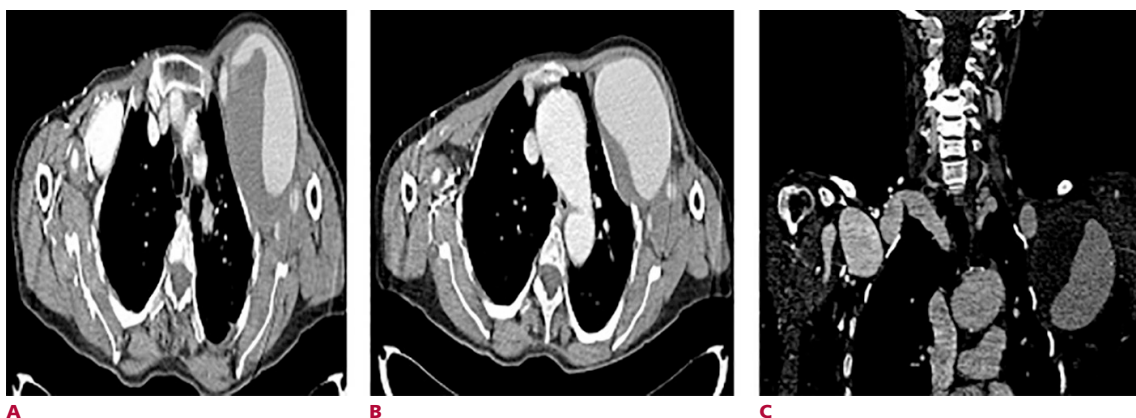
Computed tomography. A. Axial slice showing both vascular dilations at the subclavian arteries level. B. Axial slice showing aneurysmal dilation of the left subclavian artery, with both dilation and coarctation of the aorta. C. Coronal slice showing aneurysmal dilation of both subclavian arteries, the left one with a thrombus on the wall.
